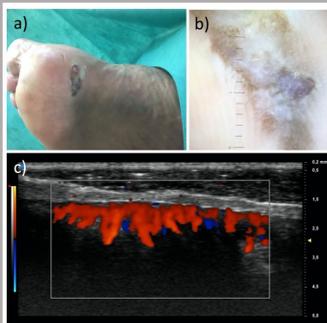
Clinical (a) and dermoscopic features (b) of an acral lentiginous melanoma. The color Doppler evaluation with UHFUS (1.9 cm/sec) shows hypervascularization of the lesion (c).
